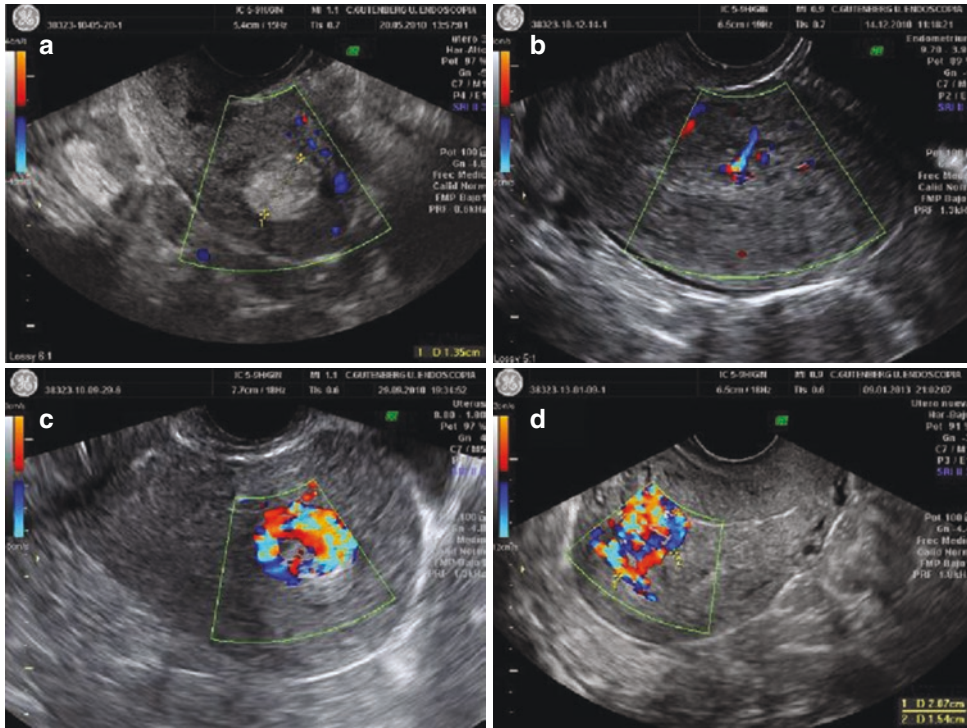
Ultrasonographic appearance of RPOC (Gutenberg classification)
